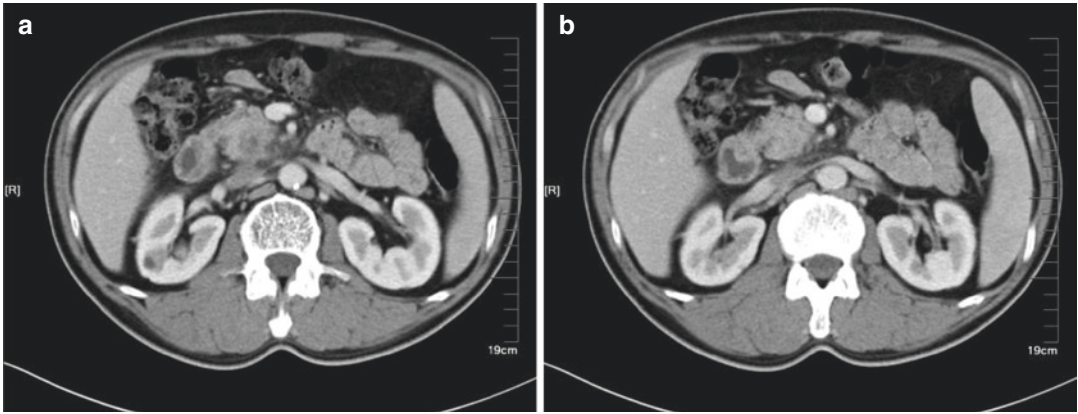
(a, b) CT image showed a mass in the head of the pancreas
